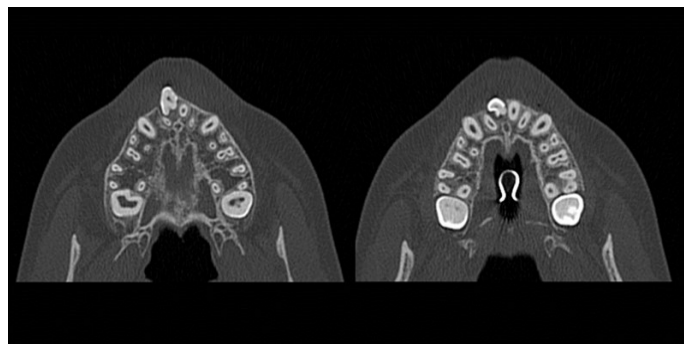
axial views of the cone beam computed tomography (CBCT), at level of impacted incisor crown revealed severe defects.
